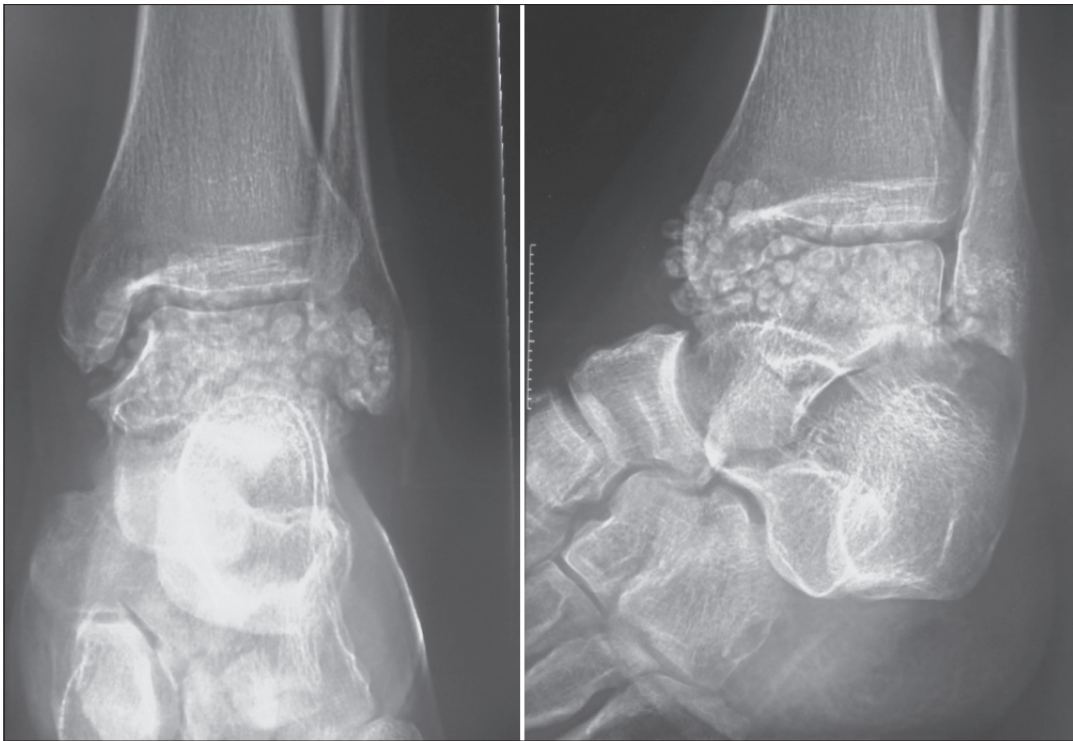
Plain weight bearing radiograph of left ankle joint showing multiple small fluffy calcified opacities at the anterior aspect of the ankle joint suggesting loose bodies along with mild soft tissue swelling. Features are suggestive of synovial chondromatosis
